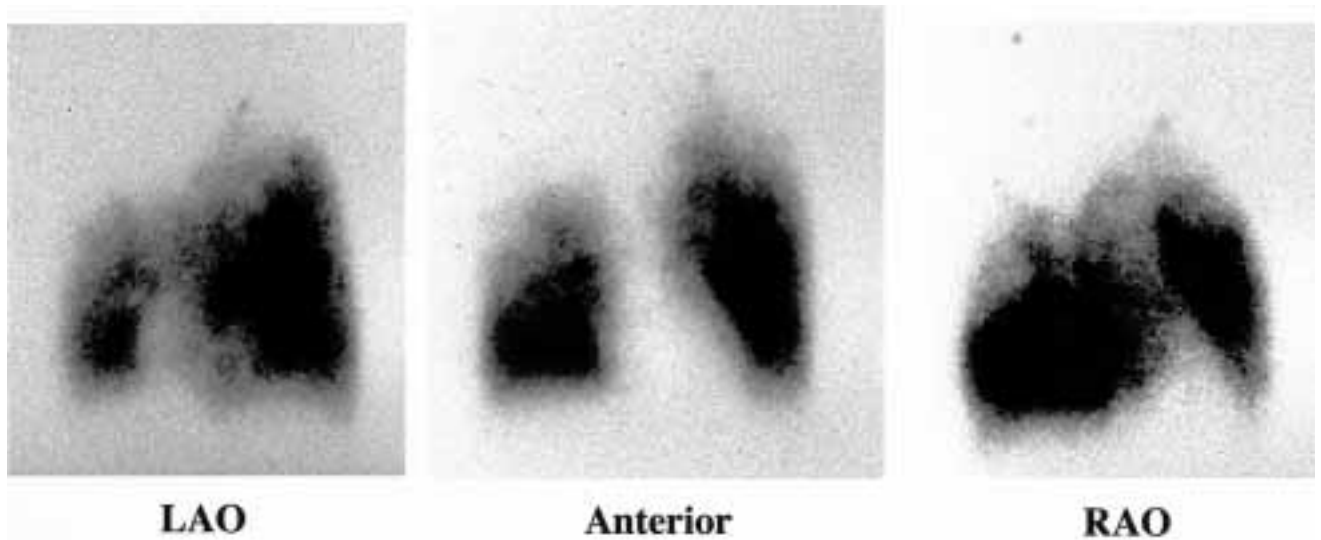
Preoperative perfusion scintigrams showed a distinct defect of the right upper lobe. Right: RAO, middle: anterior, left: LAO.
